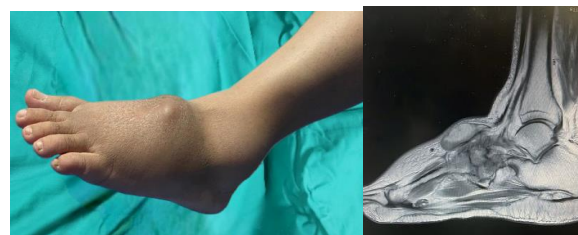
Figure shows the affected limb and T2 MRI images of the left foot.
